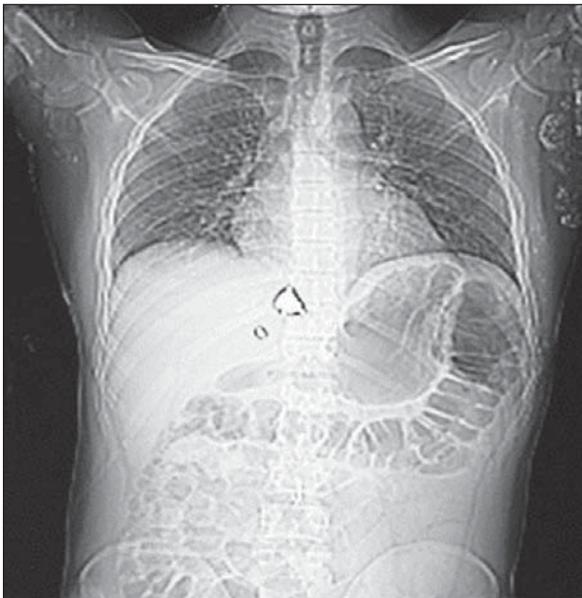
Foreign body located at the right cardiophrenic subdiaphragm is seen in thoracoabdominal X-ray.
